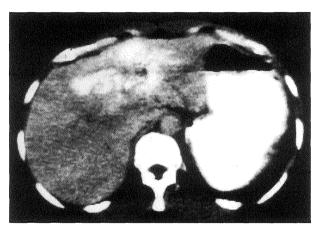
The size of the tumor was reduced to 13.3×10.5 cm after performing 4 sessions of chemolipiodolization in abdominal computed tomography.
